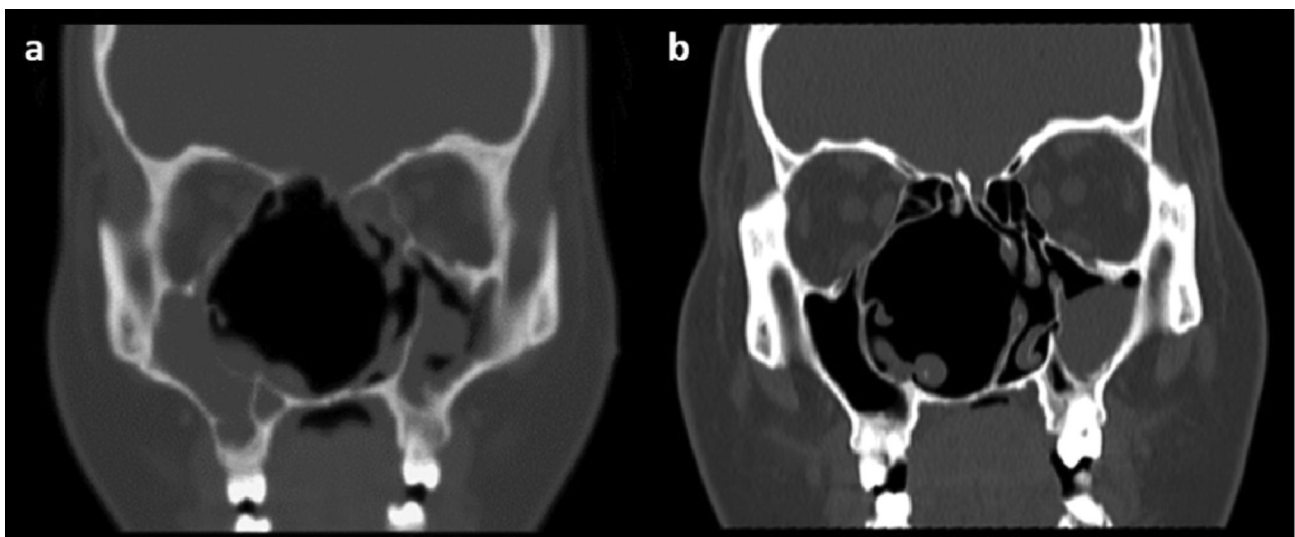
Postoperative coronal CT imaging at (a) 2 weeks and (b) 8 months. Large residual cavity without any signs of recurrence.
